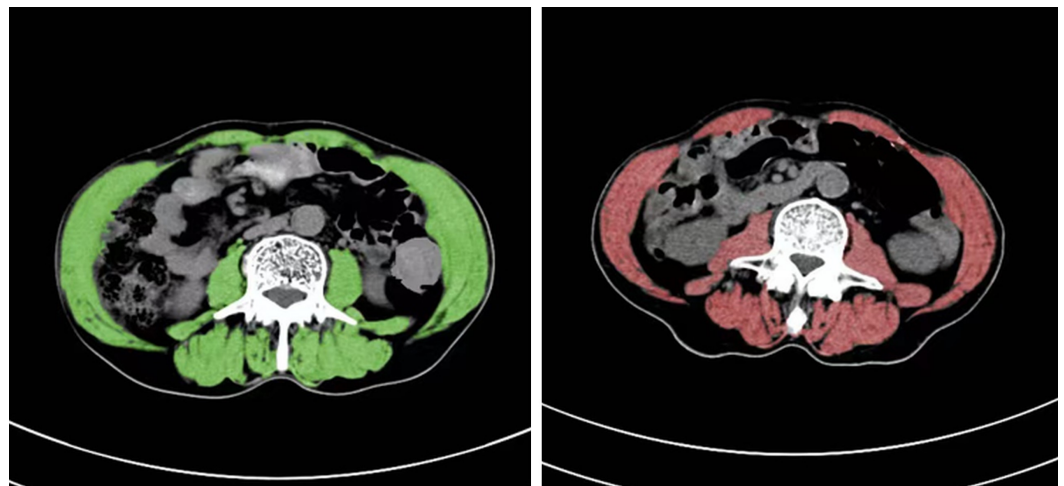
Skeletal muscle area at 3rd lumbar spine (L3) level in normal (Green) and low skeletal muscle index (SMI) patients (Red) in the abdominal computed tomography (CT) images.
